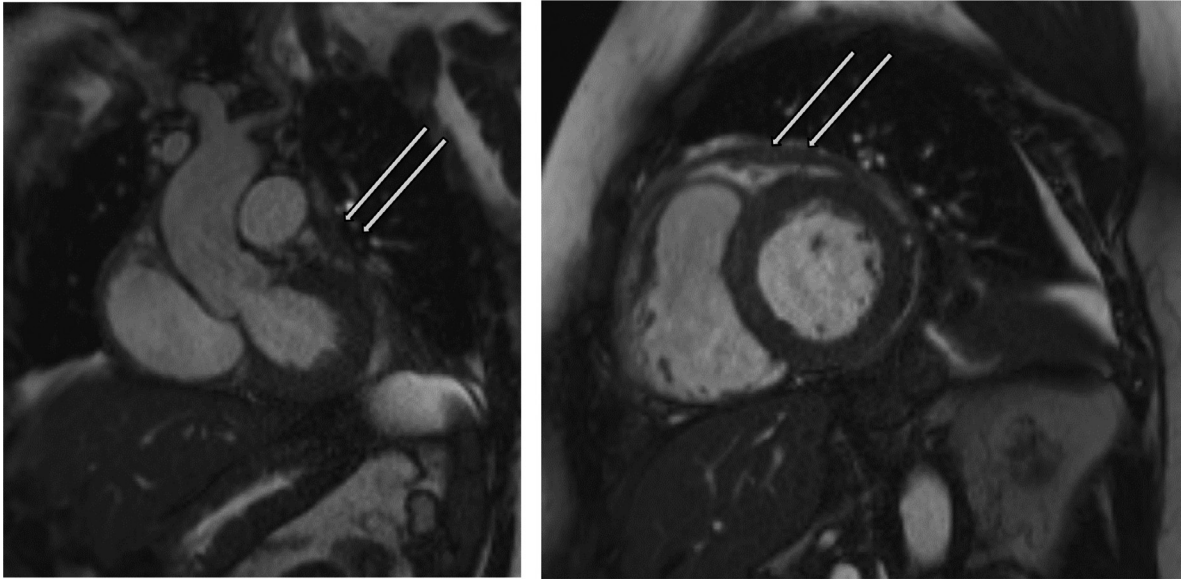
MRI of the heart showing thickening of the pericardium (arrows).
